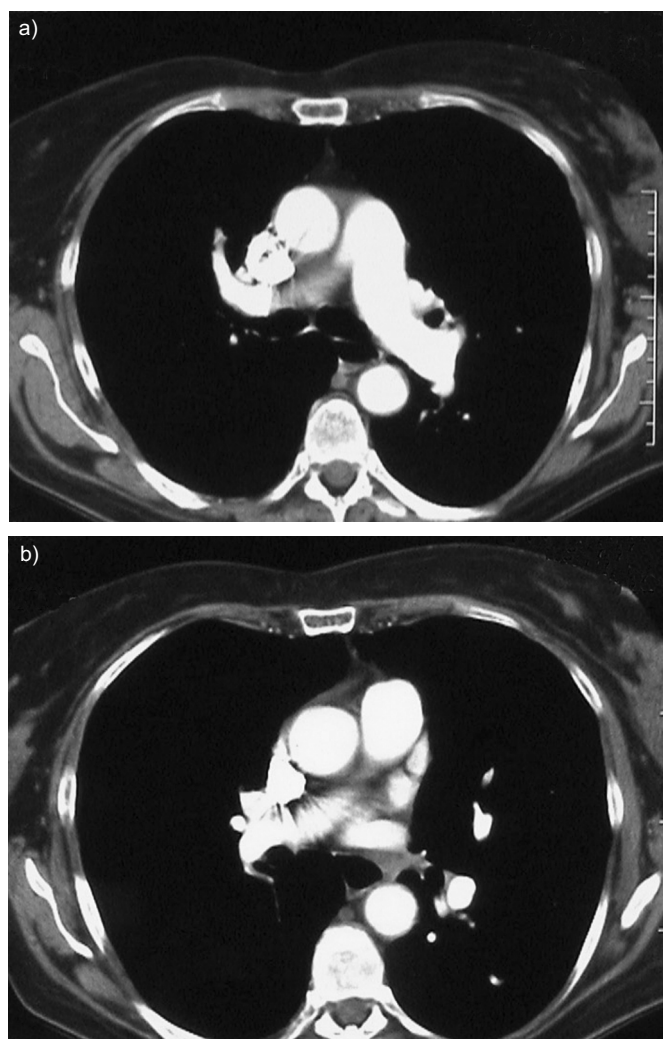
a, b) Computed tomography scan showing no clear evidence of vessel abnormalities indicative of chronic thromboembolic disease.
